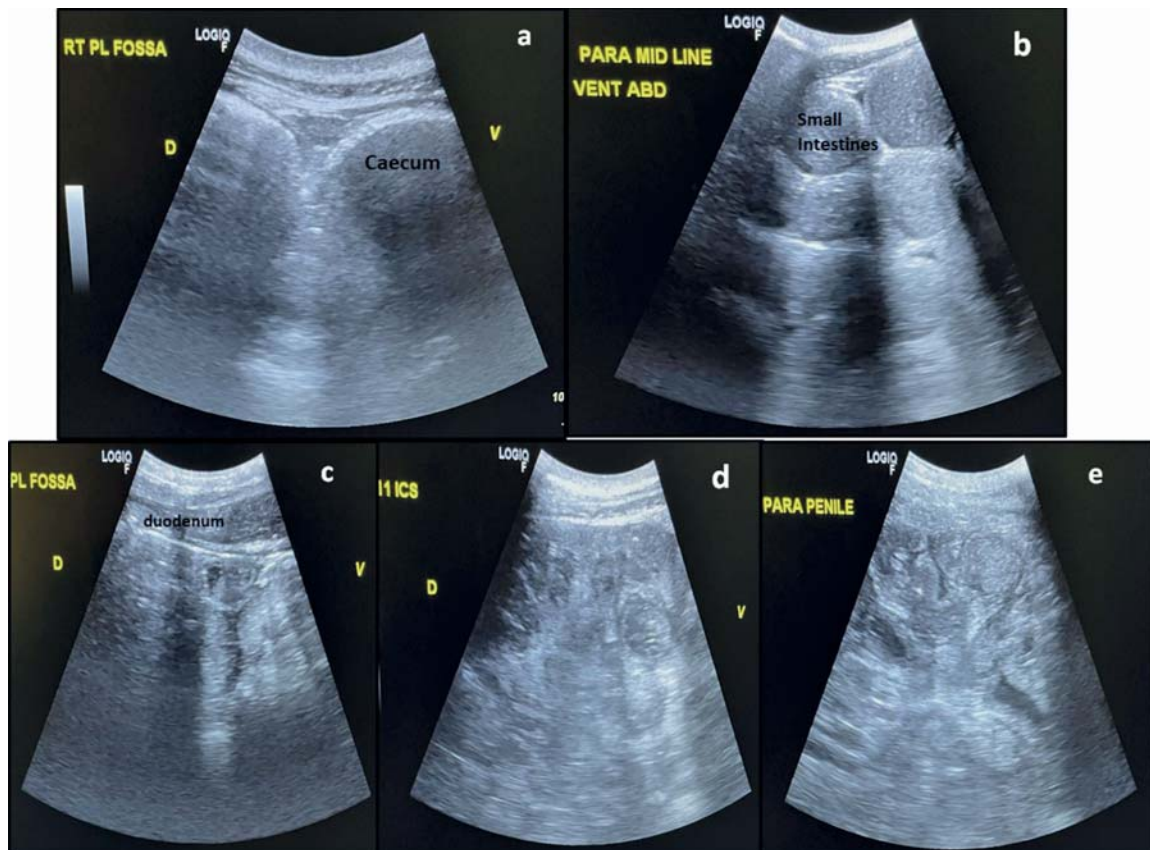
Pre-operative ultrasonogram using 5MHz curvilinear transducer in a buffalo with distended caecum (a) at right paralumbar fossa (RT PL Fossa) and dilated small intestines at para midline in ventral abdomen (b). Post-operative ultrasonogram at 24 hours in the buffalo bull with collapsed duodenum (c) in the paralumbar fossa (PL fossa), collapsed small intestines in lower flank at 11th ICS and (d) and in para-penile region of right abdomen (e) using 5MHz curvilinear transducer. D=dorsal, V=ventral.
